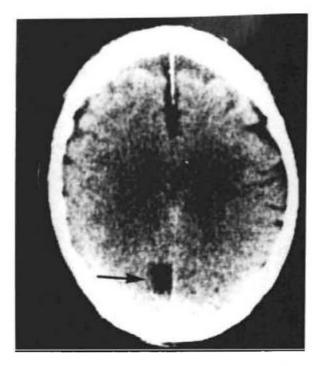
Axial CT scan made October 14, 1981. Note hypodense lesion high in right calcarine cortex (black arrow). This accounts for the left lower homonymous visual field defect in our patient.
